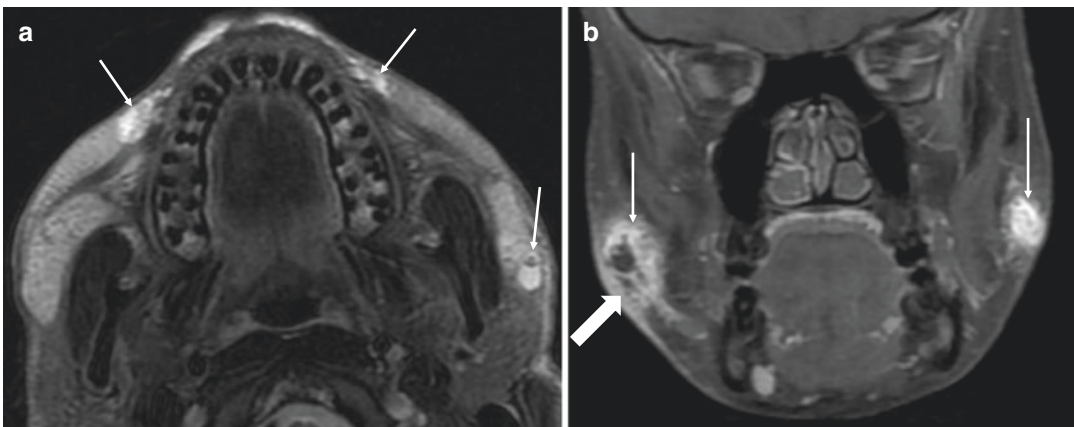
(a) Axial fat saturated T2 weighted MRI showing facial cosmetic filler as clusters of high signal material in the subcutaneous tissues bilaterally (white arrows). (b) Coronal fat saturated contrast enhanced T1 weighted MRI
